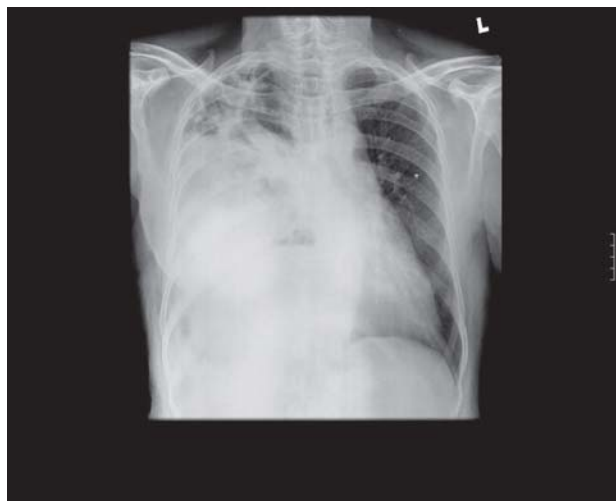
Chest radiograph (postero-anterior view) showing an inhomogeneous opacity extending over the whole of right hemithorax and causing contralateral shift of the mediastinum.
